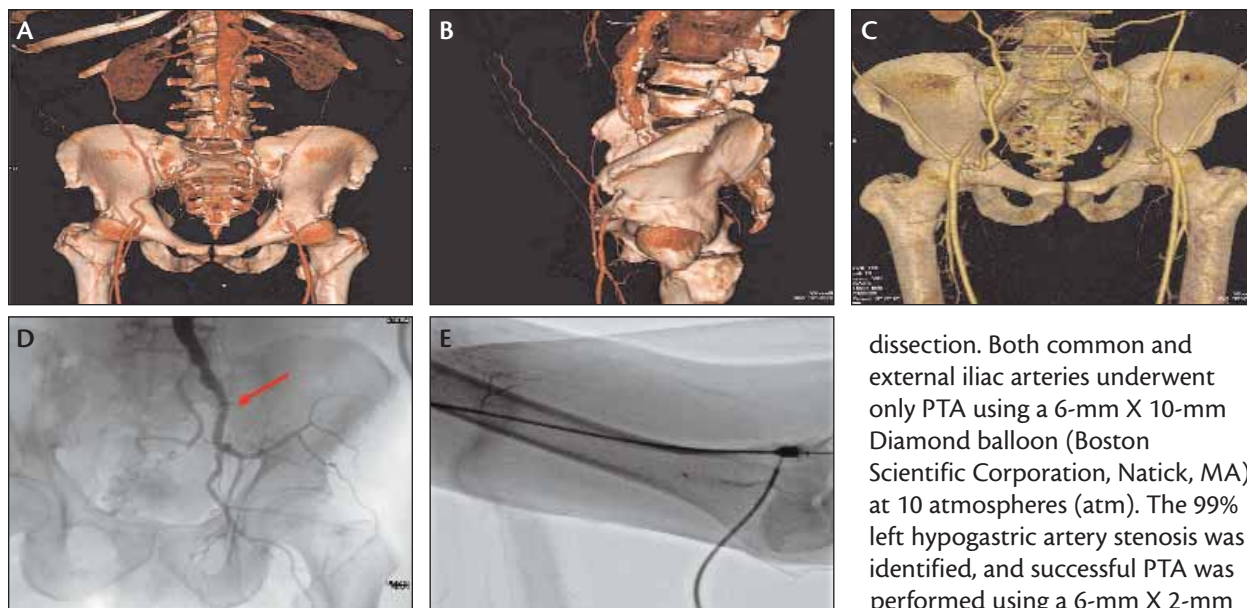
CTA of patient demonstrating bilateral iliac chronic total occlusions, total right hypogastric occlusion, severe left hypogastric disease, and both CFAs collateralized by the inferior epigastric arteries (A). Lateral CTA demonstrating the inferior epigastric arteries in this case (B). A classic example of inferior epigastric arteries completing Winslow's pathway (C). Angiography in this case correlating with the CTA results (note the arrow indicating the severe hypogastric artery stenosis) (D). Left brachial artery retrograde injection demonstrating complete 5-F sheath obstruction of flow to the forearm (E).
